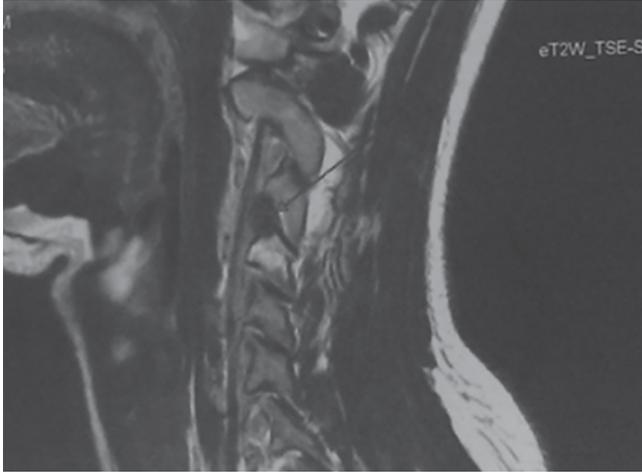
MRI of cervical spine showing well-defined rounded hypointense lesion involving the left superior articular facet of C4 vertebral body
